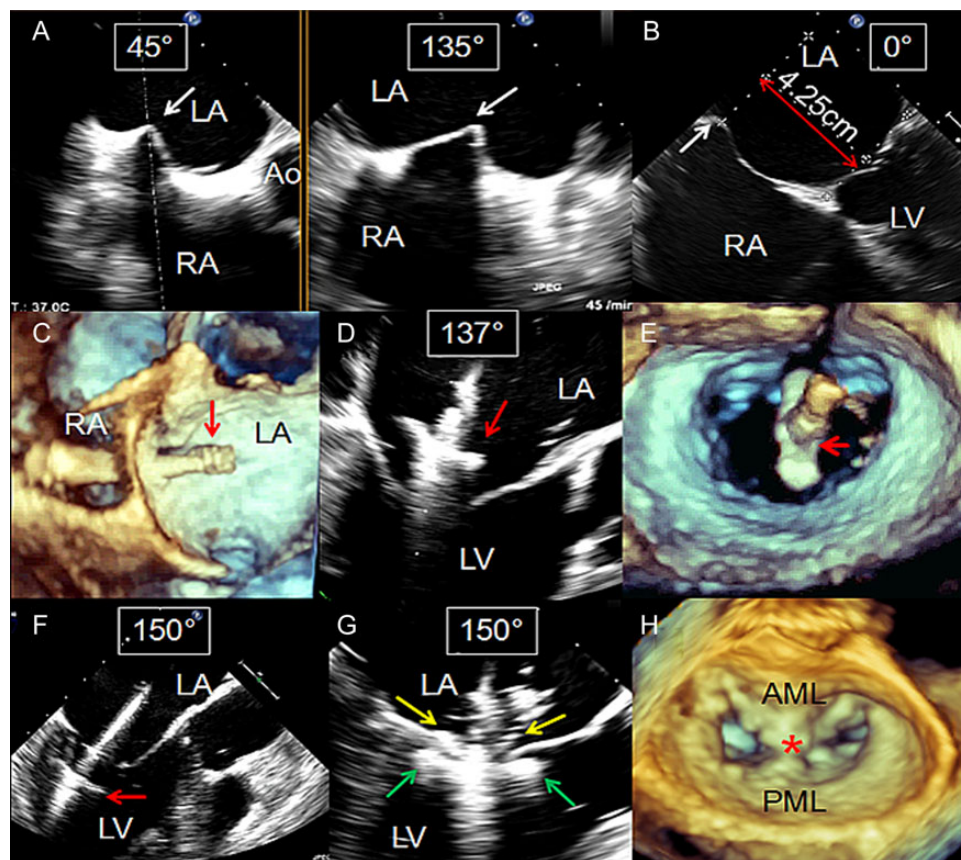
Procedural steps. (A) x-Plane imaging of the interatrial septum is shown. The tip of the transeptal needle is identified by a tent-like doming of the interatrial septum (marked with a white arrow) in a short-axis view (left) and in a long-axis (bicaval) view (right). (B) Height above the MV is measured in a four-chamber 2D TEE view (in this case 4.25 cm above the mitral annulus, which is appropriate). The white arrow marks the 'tenting' in the interatrial septum. (C) Steerable guide catheter (SGC) is positioned in the LA. The tip of the SGC is marked with a red arrow. (D) MitraClip device is positioned above the mitral valve. In this long-axis view both Clip arms can be seen in full length. (E) The correct orientation of the Clip (red arrow) perpendicular to the line of coaptation in an LA 3D enface view. (F) The Clip (red arrow) in the LV in a LVOT view with both leaflets freely moving above the Clip. (G) The grasping of the leaflets is shown. The leaflets can be identified between the Clip arms (green arrows) and the grippers (yellow arrows). (H) The final result is seen in a 3D enface view from the LA. The newly created tissue bridge is marked with a red star. Two orifices can be identified medial and lateral. LA, left atrium; RA, right atrium; LV, left ventricle; LVOT, left ventricular outflow tract; MV, mitral valve; AML, anterior mitral leaflet; PML, posterior mitral leaflet; TEE, transoesophageal echocardiography.
